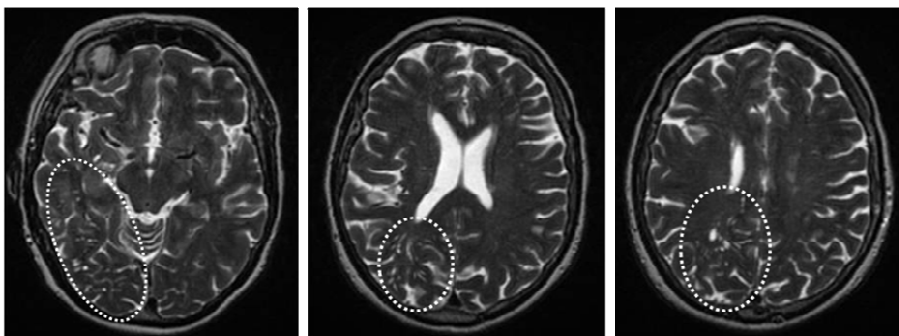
A. Asymmetry of background brain parenchyma due to an infarct in the right parieto-occipital lobe on T2-weighted MRI (arrow). B. Fully cavitated (short arrow), partially cavitated (thick arrow) and probably non-cavitated (arrowhead) lacunar lesions in the basal ganglia on T2 and FLAIR MRI. The exact nature of the lesion indicated by the long arrow is less certain - this could represent a cavitated lacune or EPVS with surrounding WMH
